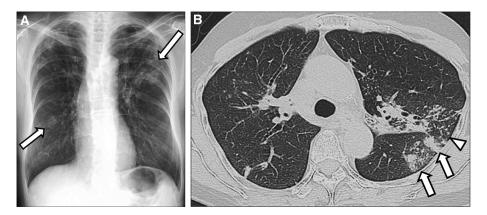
Tuberculosis. Pulmonary tuberculosis in a patient with rheumatoid arthritis treated with tumour necrosis factor inhibitors (infliximab) and methotrexate. (A) Chest radiograph, showing consolidation in bilateral lobes (arrows). (B) High-resolution computed tomography, showing centrilobular foci consolidation (arrow), nodules, and branching opacity (tree-in-bud appearance [arrowhead]) in the left upper lobe. *Mycobacterium tuberculosis* was identified from sputum.
